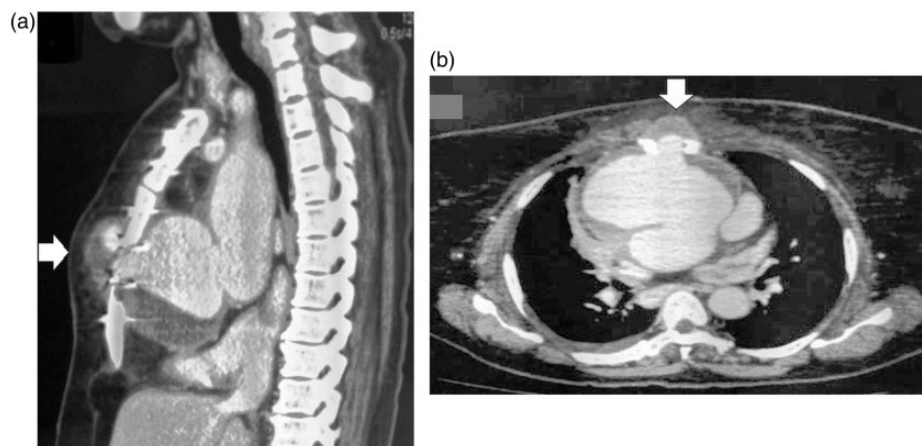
Preoperative computed tomography angiograms demonstrating a pseudoaneurysm of the ascending aorta eroding through the sternum into the subcutaneous tissue in (a) case 1 and (b) case 2.
